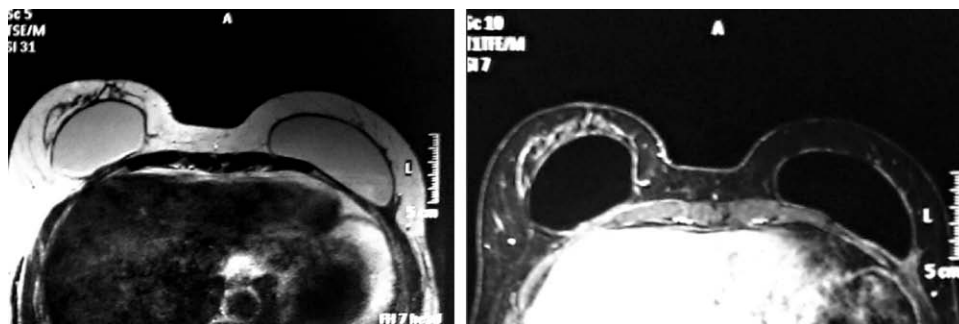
No clinical complication was observed after the breast implant inclusion. Controls have not shown any evidence of breast cancer relapse after 8 years of mastectomy, 3 years of lipofilling, and 2 years of breast implant. Magnetic resonance imaging controls (pictures above) show the maintenance of subcutaneous thickness without any sign of capsular contraction or radiological findings at the reconstructed breast.
